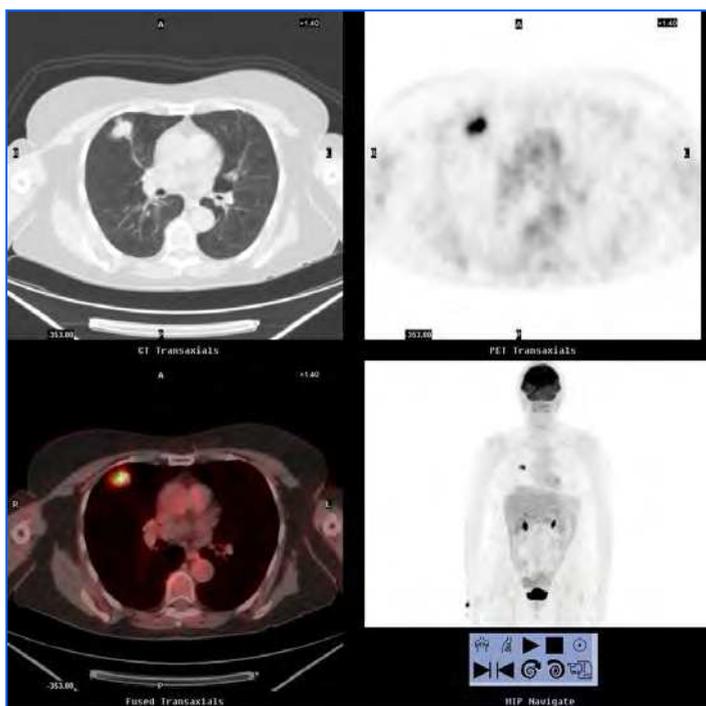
False positive: Axial section of CT, PET and combined images and coronal section of the PET study. The pulmonary nodule of the right upper lobe shows an intense uptake of ^{18}F FDG in the PET and combined image. The anatomopathological analysis revealed a tuberculoma in a patient with colon carcinoma.
